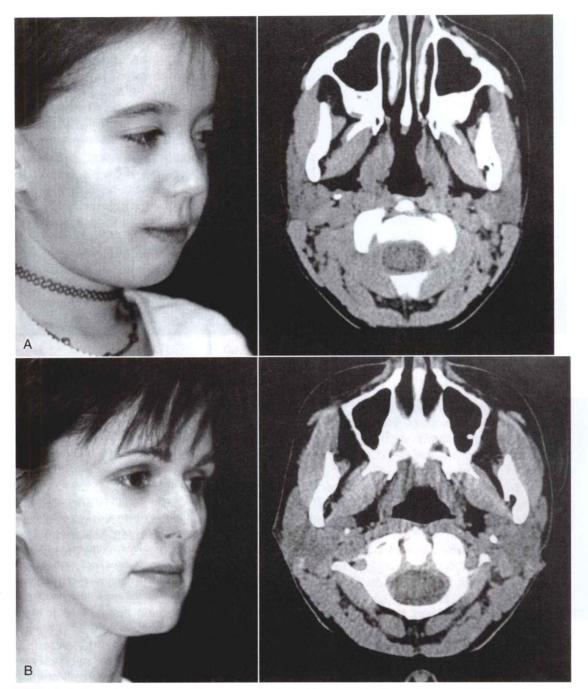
A, Computed tomography (CT) scan showing the facial anatomy of a 9-year-old female. B, CT scan showing the facial anatomy of a 42-year-old female.
